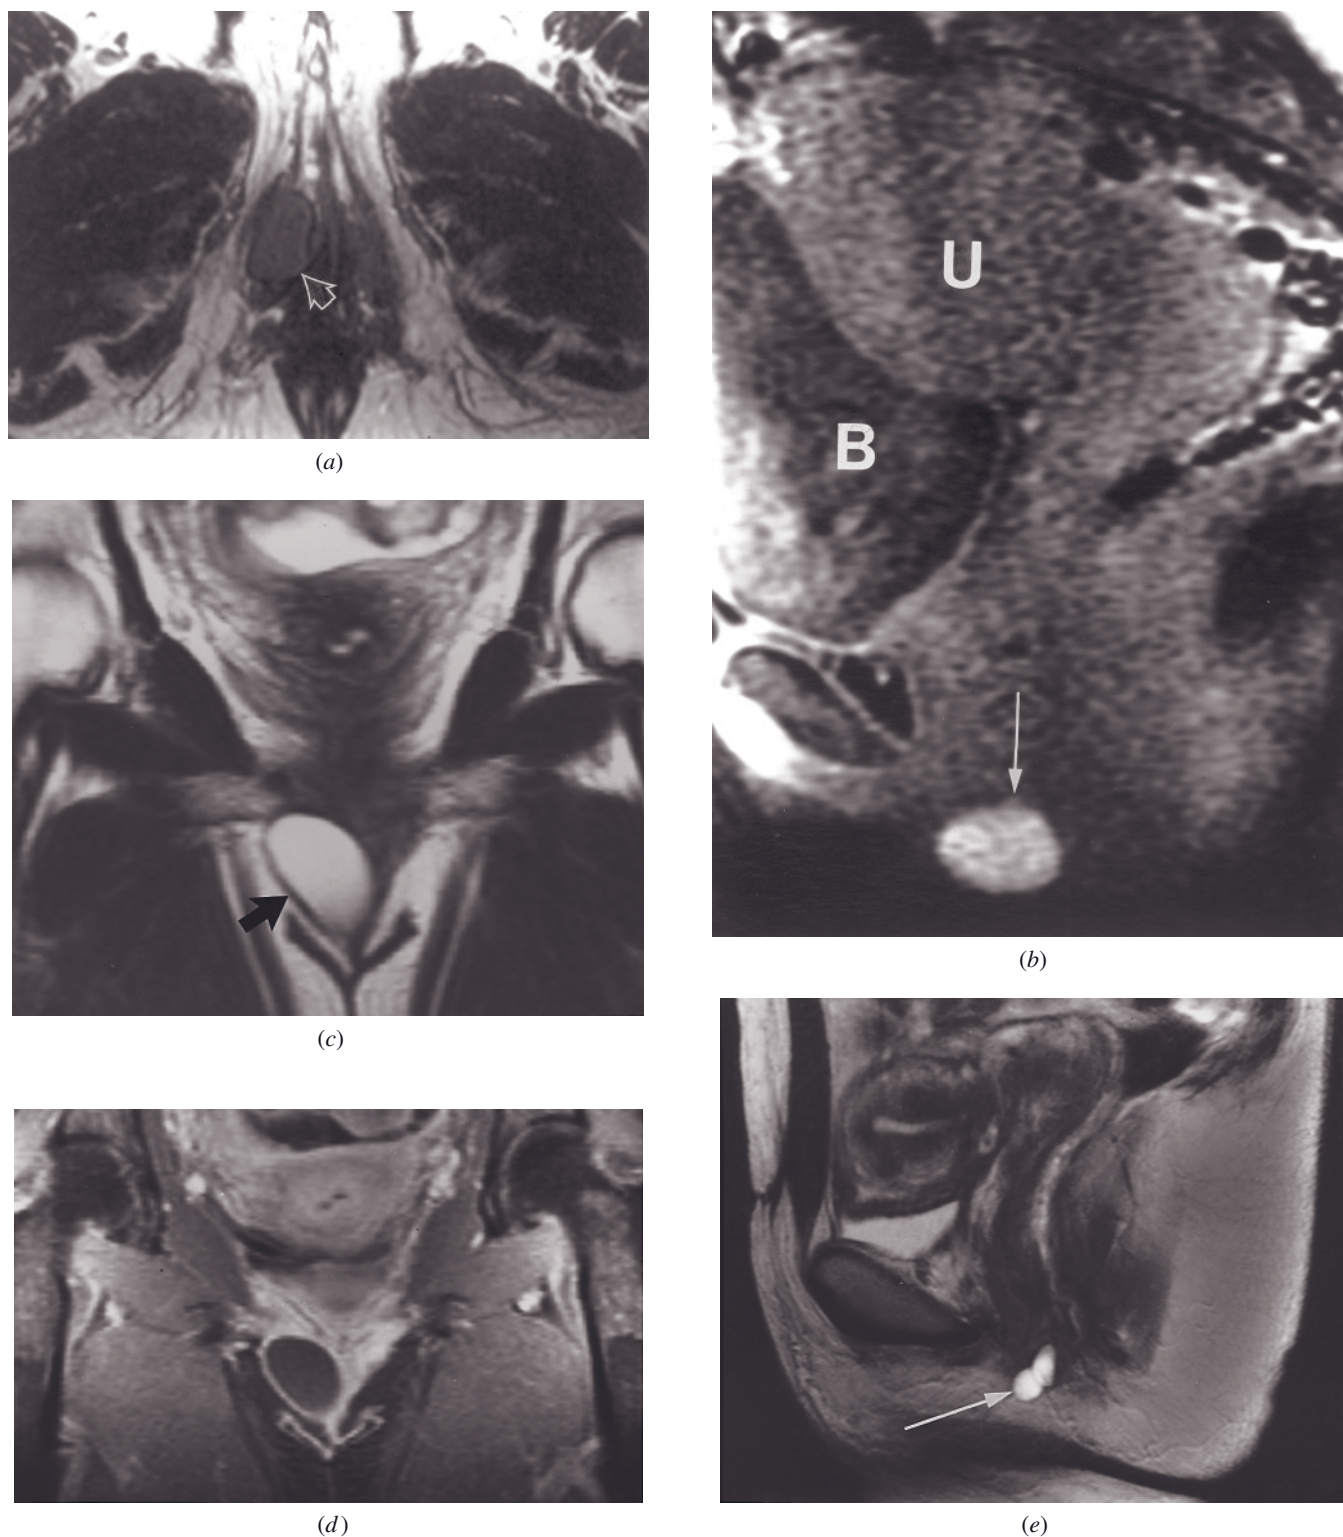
Asymptomatic Bartholin gland cyst. Transverse T2-weighted ETSE (*a*) and sagittal T1-weighted fat-suppressed SGE (*b*) images show a low-signal-intensity mass on the T2-weighted image (arrow, *a*) within the lateral aspect of the distal vagina near the introitus. On the sagittal T1-weighted fat-suppressed image this mass appears high signal intensity because of high protein content (arrow, *b*). B, bladder; U, uterus. Coronal T2-weighted ETSE (*c*) and coronal gadolinium-enhanced fat-suppressed SGE (*d*) images in a second patient. The cyst is high in signal intensity on the T2-weighted image (arrow, *c*) and demonstrates an enhancing cyst wall with low-signal-intensity cyst contents on the postgadolinium image (*d*). Sagittal 512-resolution T2-weighted ETSE (*e*, *f*) images in two other patients show Bartholin duct cysts (arrows, *e*, *f*).
